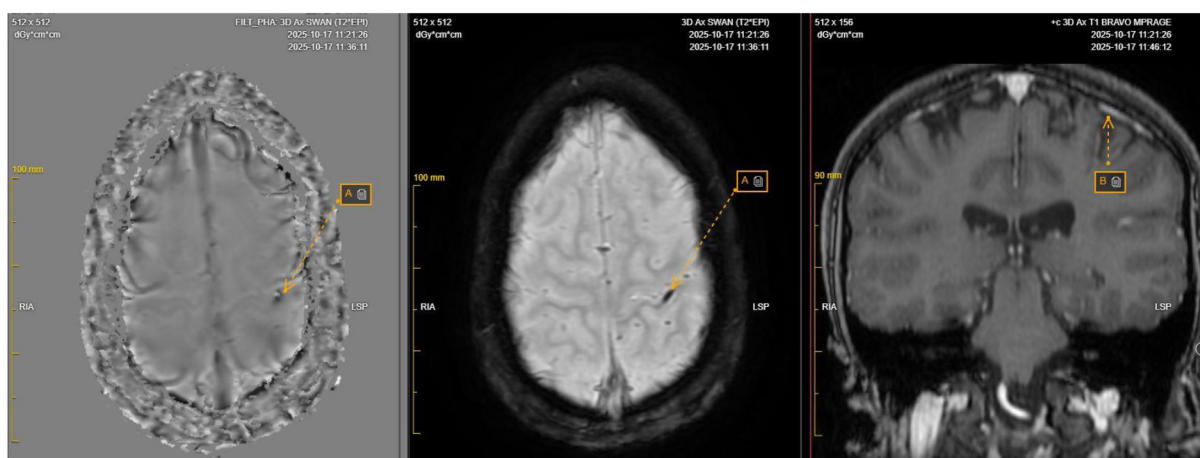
Brain MRI scan (left to right: Susceptibility-weighted imaging (SWAN), SWAN calcium filter, SWAN, T1-weighted with contrast media cor): an elongated focus of hemosiderin microdeposition with microcalcification on SWAN calcium filter in the region of the left central sulcus (A). This finding is not visualized on other MRI sequences. The Trolard vein is going along and identified with no changes (B). No imaging features of cytotoxic edema or encephalomalacia are observed in the perifocal cerebral cortex.
